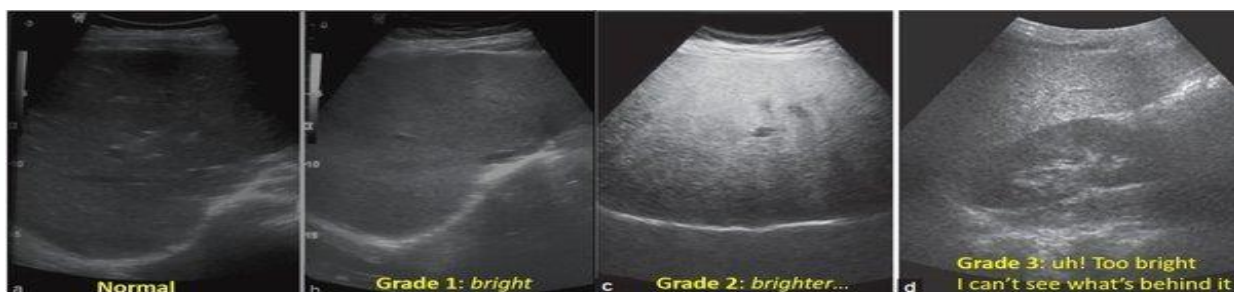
exhibits the grades of Fatty Liver on Ultrasound.
